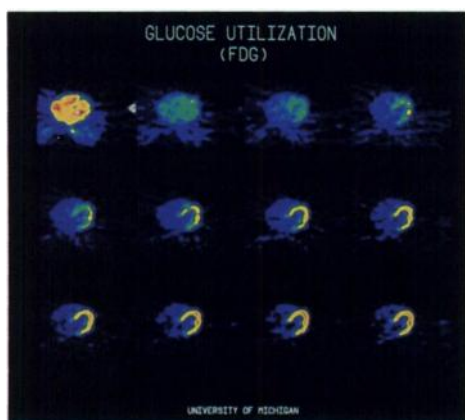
Accumulation of FDG within the heart is determined by the net rate of glucose extraction and phosphorylation by the heart. In this dynamic series of images of a single, mid-ventricular transaxial slice, progressive accumulation of FDG in the heart occurs during the 1-hr imaging period. The PET images in this and the following figures were acquired using a whole-body Siemens 931 PET instrument.
